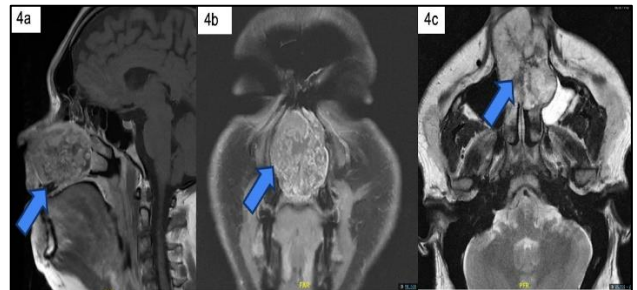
MRI PNS showed the solid anterior-mid nasal mass demonstrating iso-intense signal to skeletal muscle on T1W (4a, 4b), and heterogeneous hyperintense signal on T2W (4c). The sunburst periosteal reaction at the centre of this mass appears hypointense on all sequences. a: sagittal view, T1W; 4b: coronal view, T1W; c: axial view, T2W.
